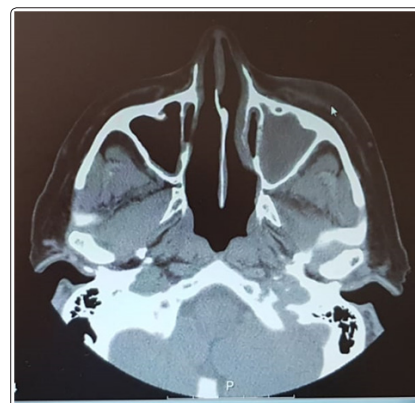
CT-scan at first evaluation, with signals of rhinosinusitis with associated post-septal cellulitis, May 2017
